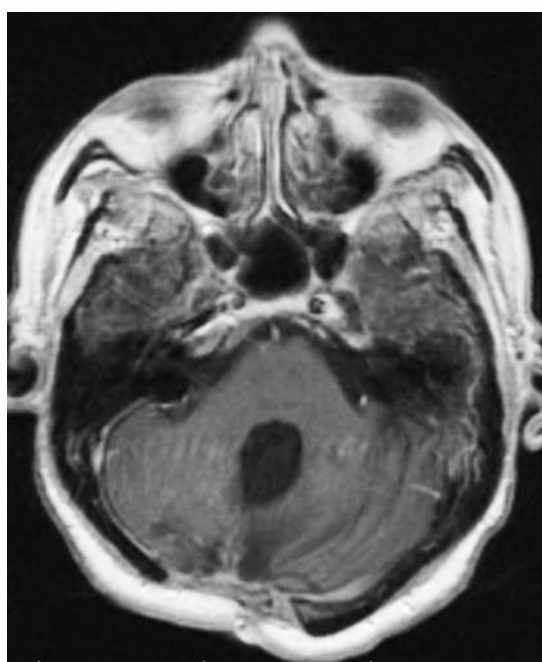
Postoperative MRI shows no residual tumor
